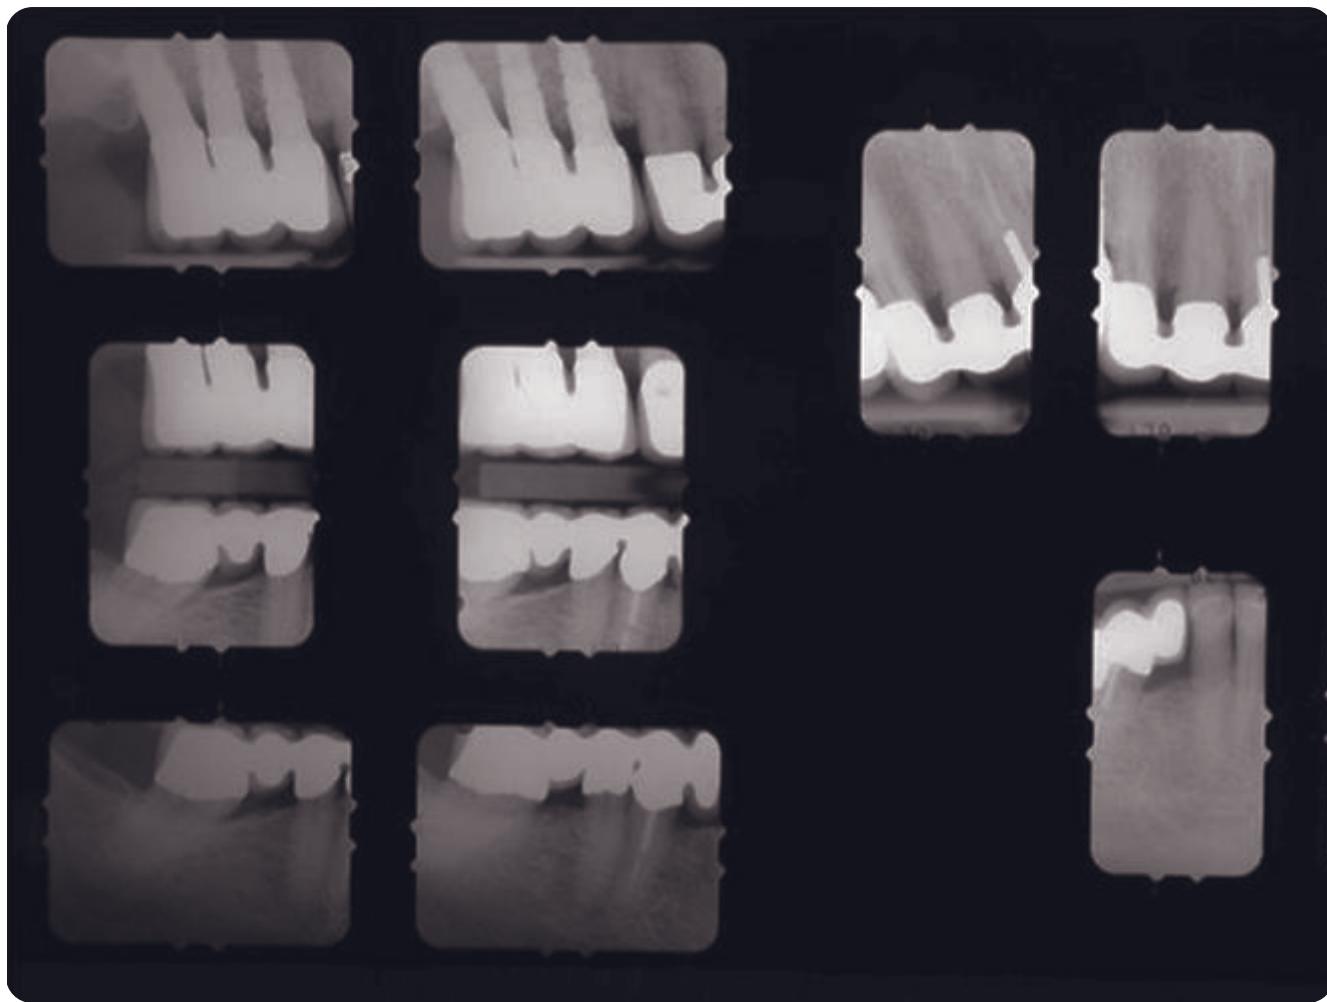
Posttreatment radiographs, right posterior.
